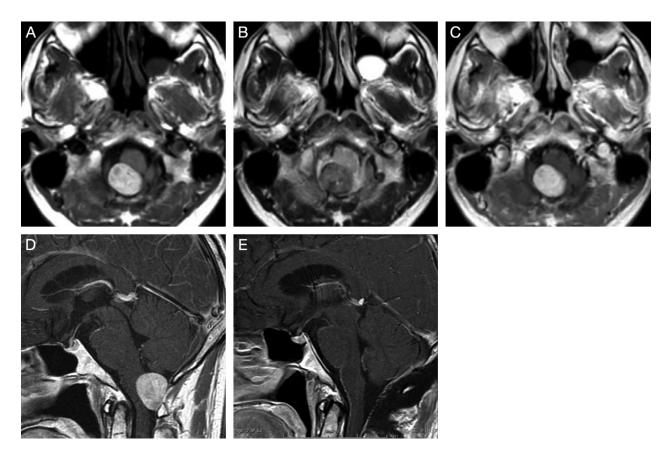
MRI. (A) Axial T1-weighted MRI shows a well-circumscribed hyperintense lesion in the foramen magnum. (B) Axial T2-weighted MRI reveals hypointensity. (C, D) Axial and sagittal gadolinium-enhanced T1-weighted MRI shows an intradural extramedullary mass lesion in the foramen magnum is compressing the dorsal brainstem. The contrast enhancement is not evident. (E) Postoperative axial gadolinium-enhanced T1-weighted MRI show gross total removal. MRI: magnetic resonance imaging.
